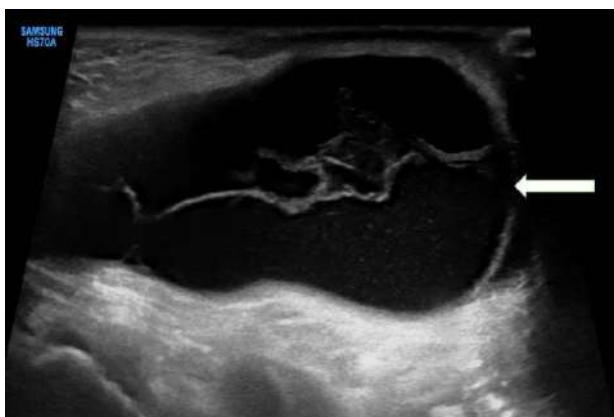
On B-mode ultrasonography, an anechoic oval cystic lesion (white arrow) is seen with multiple septat
